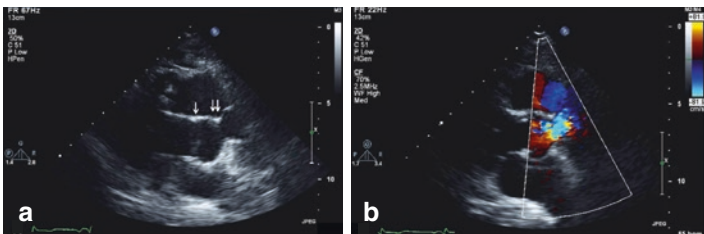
Echocardiographic imaging showing a supravalvular stenosis. In image (a), the single arrow is pointing to the aortic valve annulus, and the double arrow is pointing to the supravalvular stenosis. Image (b) shows turbulence in the ascending aorta in the location of the supravalvular stenosis
